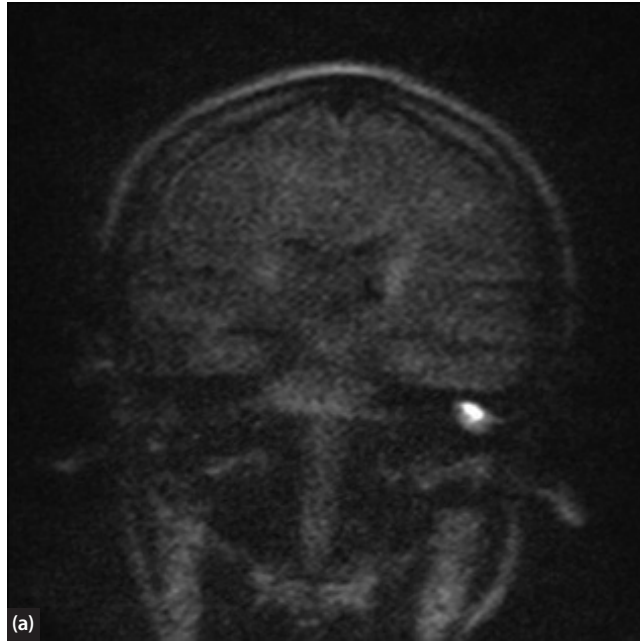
Coronal DWI MRI shows left sided high signal on the b1000 sequence (a) with matched low signal on the ADC map (b), compatible with left sided cholesteatoma.
